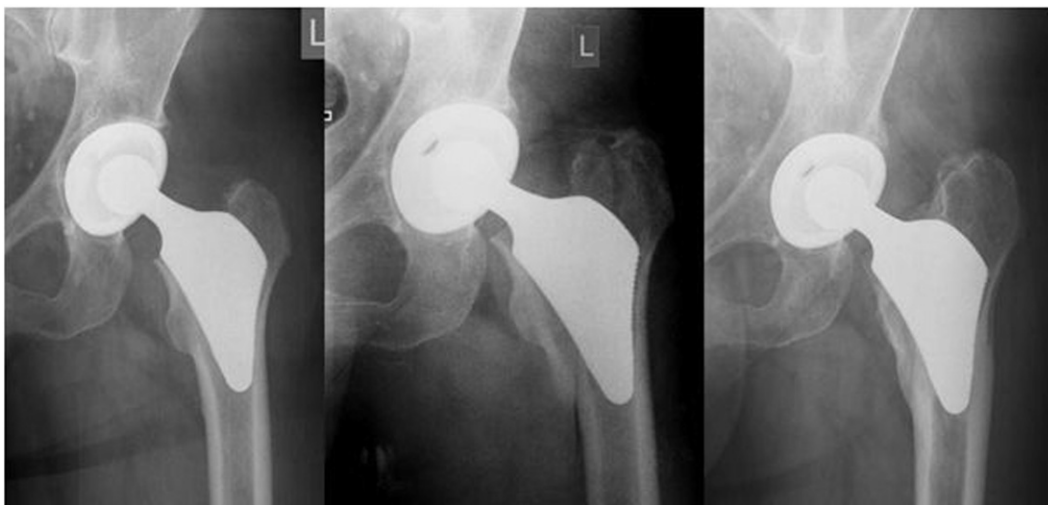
a: Immediate postoperative radiograph of left hip following uncemented THR using the Proxima short stem in a 48 year old male patient. b: 3 weeks post THR patient had a fall and suffered a what was deemed to be a Vancouver B1 femoral fracture. The fracture was treated conservatively. c: 5.5 years post THR. The hip is asymptomatic with excellent function. The fracture has healed and remodeled.
